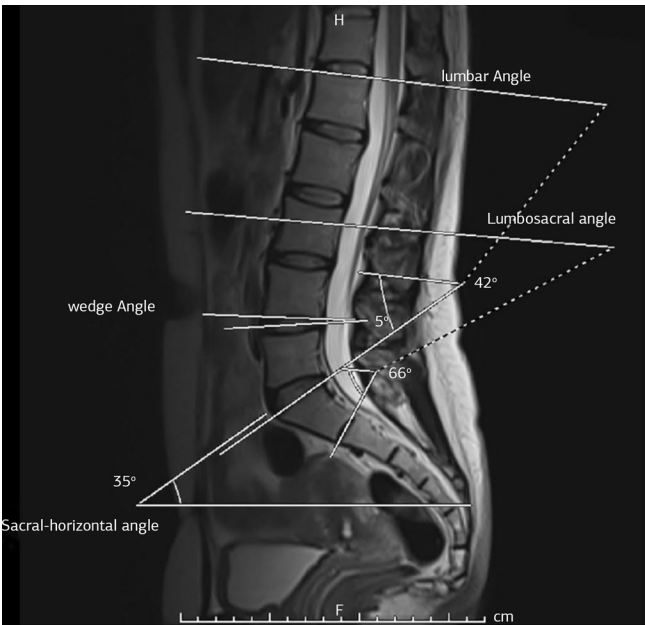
Measurements of lumbar angle, lumbosacral angle, wedge angle, and sacral horizontal angle of a patient MRI images
